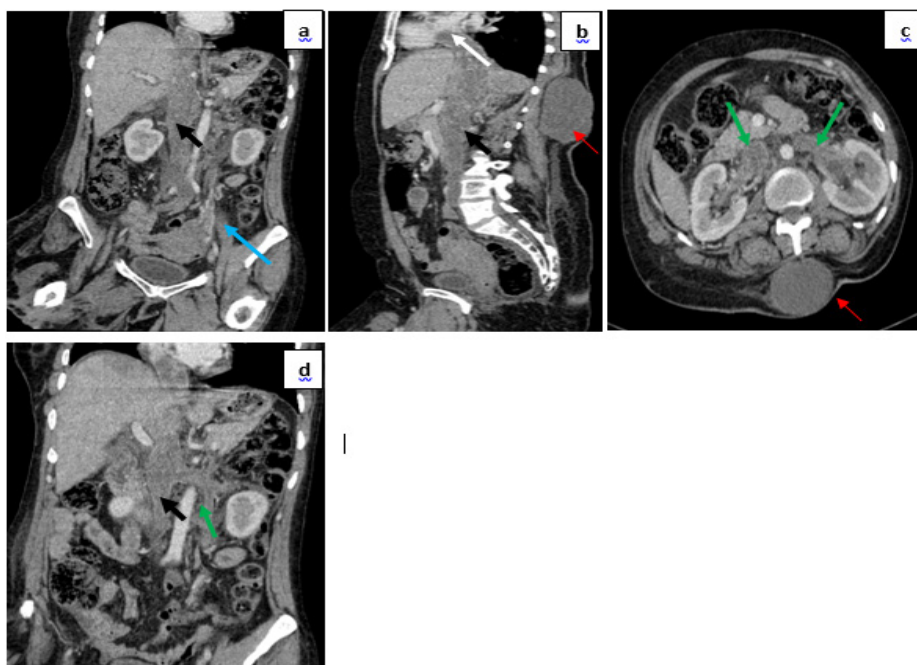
Contrast-enhanced thoraco-abdomino-pelvic CT scan revealing intraluminal material within the Inferior Vena Cava (IVC) (Black arrow) (a,b,d), extended to the right atrium (White arrow) (b), renal veins (Green arrow) (c,d), and common iliac veins (a) (Blue arrow).
